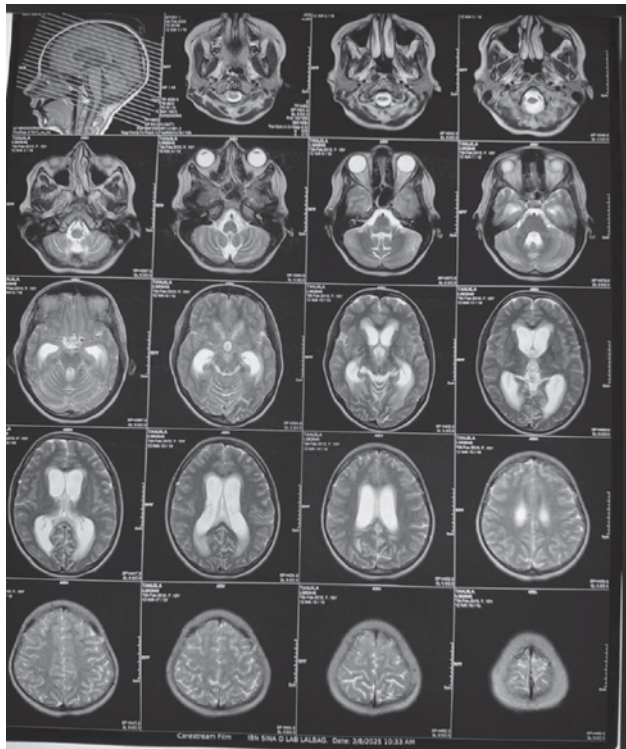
T2 sequence of MRI Brain shows lateral & third ventricles are mildly dilated, 4th ventricle appears normal
